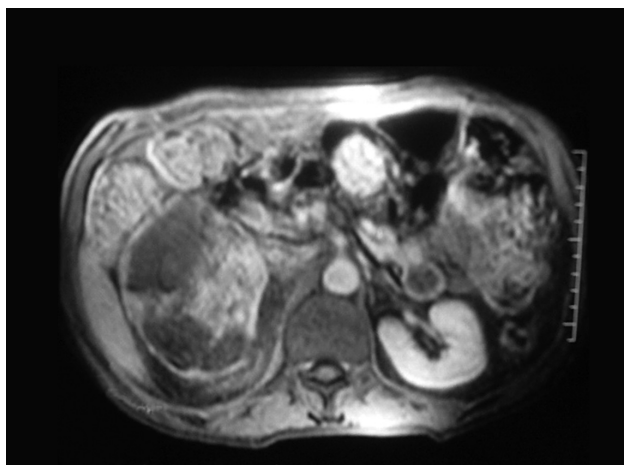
Abdominal MRI (T1-weighted image) reveals a right adrenal mass, hemorrhagic in character, having necrotic areas and septations. The right kidney was pushed inferiorly by the mass.
